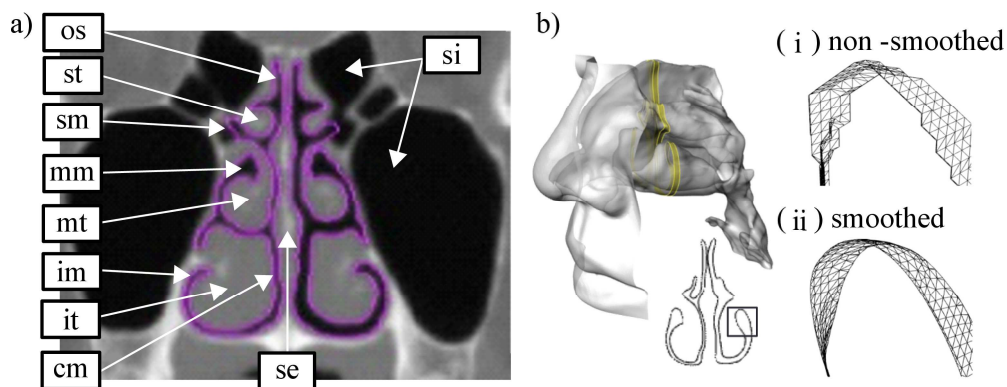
Procedure for polygon model generation. (a) CT images: os, olfactory slit; st, superior turbinate; sm, superior meatus; mm, middle meatus; mt, middle turbinate; im, inferior meatus; it, inferior turbinate; cm, common meatus; se, septum; si, sinus; (b) polygon model.
